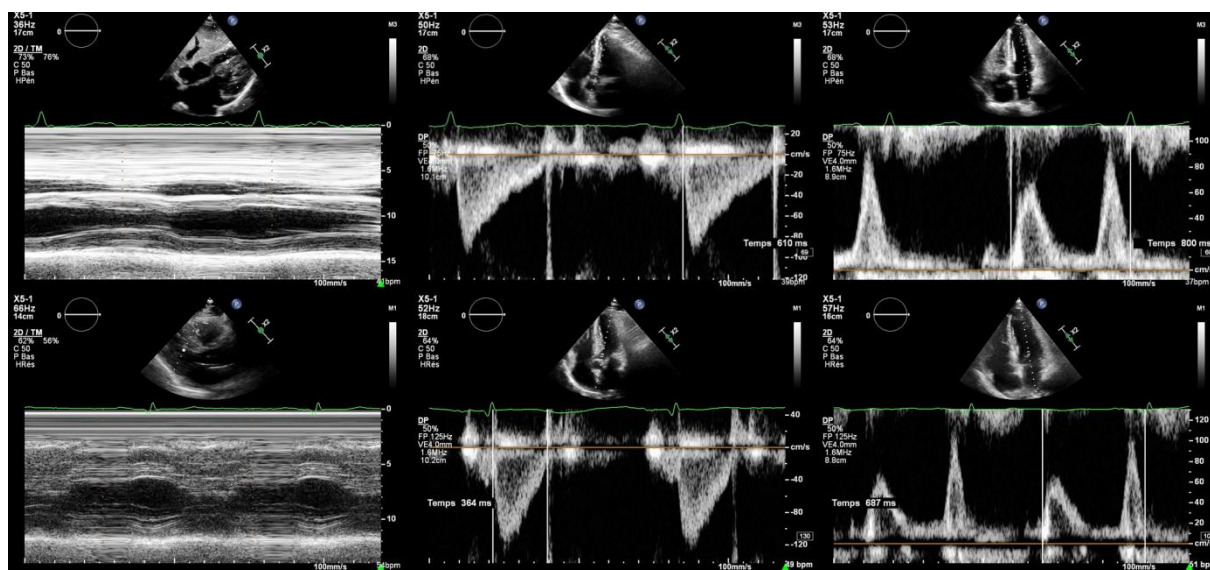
Comparison of left ventricular M-mode and pulsed wave Doppler through aortic and mitral valve in the same patient in hypothermia (at the top) and in normothermia (below).
